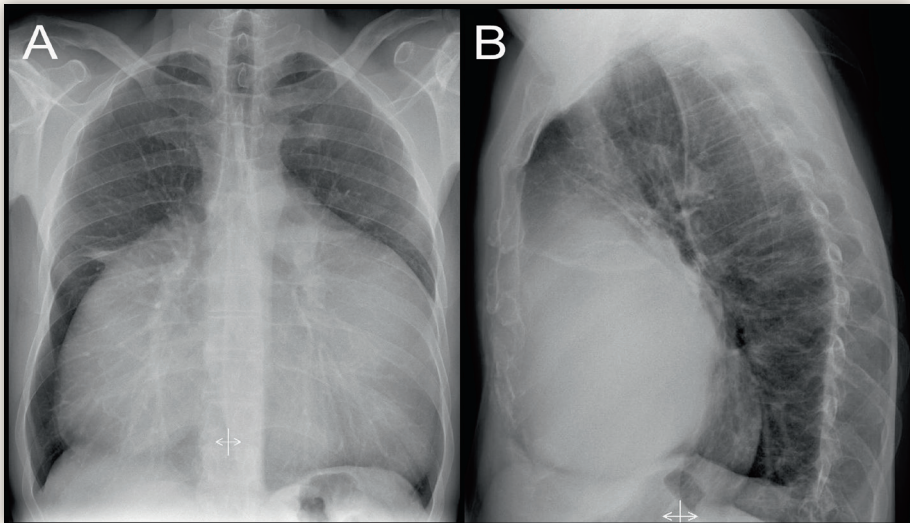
Preoperative posterioranterior (A) and lateral (B) chest X-ray showing a large mass in the anterior mediastinum with posterior displacement of the heart.
